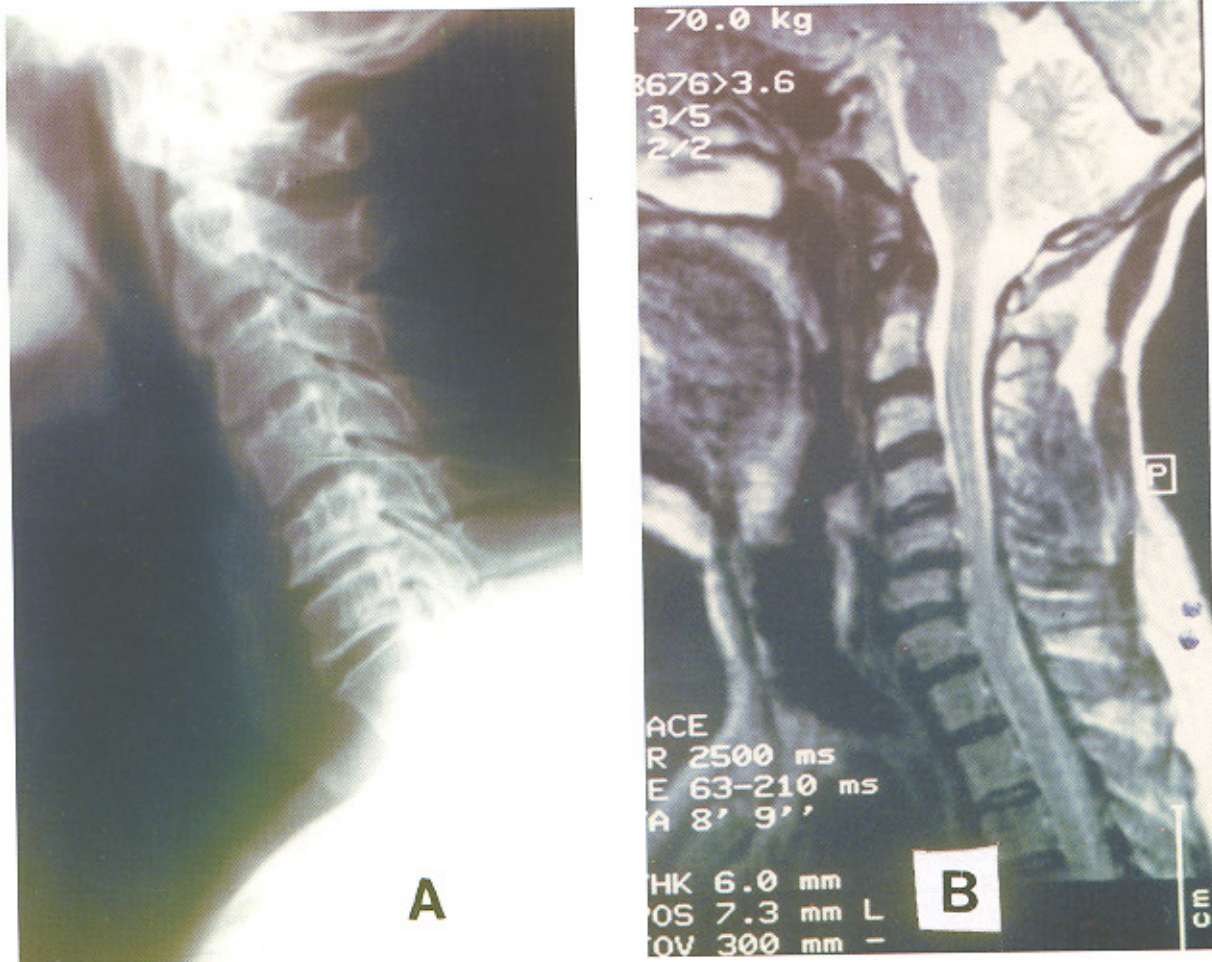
Lateral cervical radiogram (A) and MRI (B) of a 52 year old wrestler with 31 years history of wrestling
